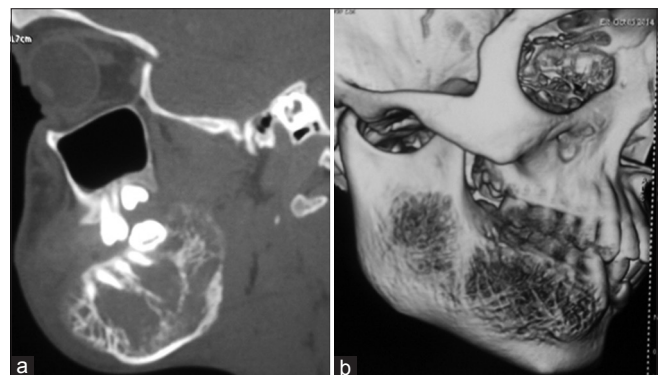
(a) Sagittal view showing the involvement of right mandibular body and ramus. (b) Three-dimension computed tomography showing multiple septa and cortical breaks in the outer cortex of body and ramus region
